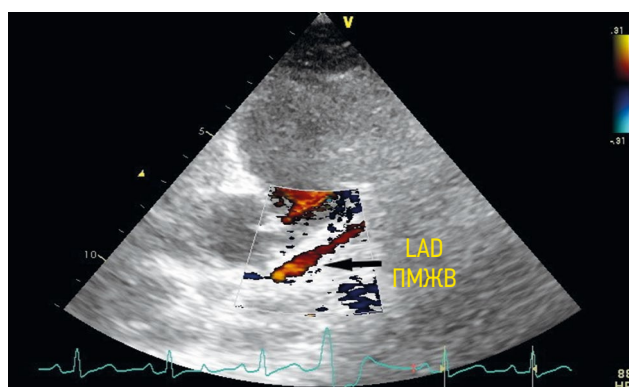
Visualization of the anterior interventricular branch from a modified left parasternal position. LAD — left anterior descending artery
